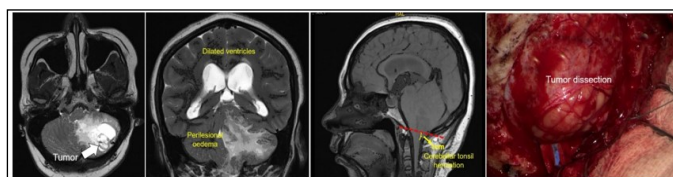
(from left to right): Cerebellar tumour with perilesional oedema in MRI axial section, coronal section, cerebellar tonsil herniation in MRI sagittal section, and left cerebellar suboccipital craniotomy and tumour excision.
